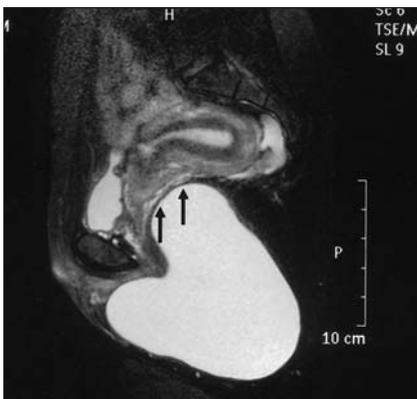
Sagittal T_2 -weighted magnetic resonance image of the pelvis showing the hyperintense unilocular cystic lesion with elevation of the levator ani muscles (arrows)
